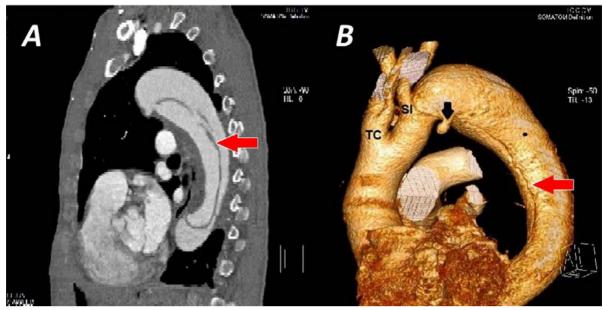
Computed tomography with contrast. A. Left lateral view at chest level, where the aortic dissection and intimal flap are observed (arrow). B. Tridimensional reconstruction where the emergency of the brachiocephalic arterial trunk and the left common carotid artery of a common trunk (TC [acronym in Spanish]) is observed. The beginning of the dissection (red arrow) after the left subclavian artery (SI [acronym in Spanish]) is also displayed. The black arrow indicates the remnant of the ductus arteriosus.
